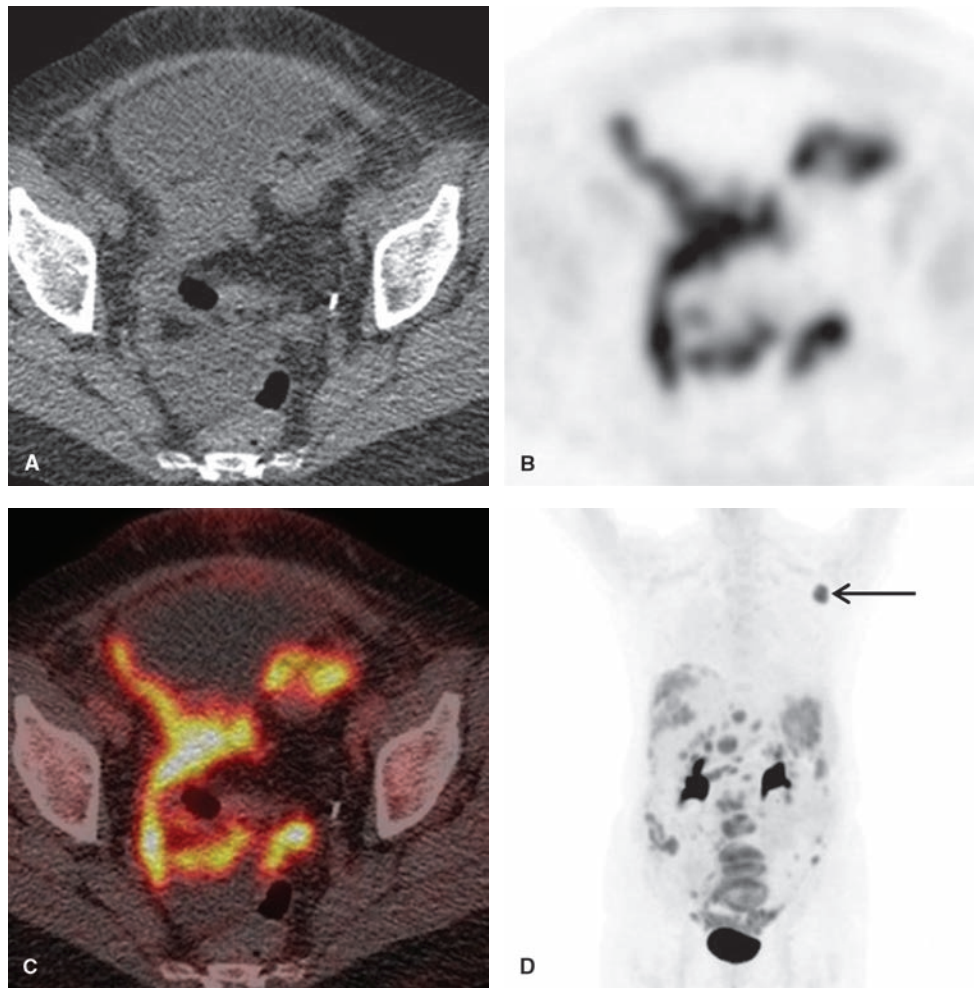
Recurrent ovarian carcinoma. Unenhanced CT image (A), FDG-PET image (B), and fused PET/CT image (C) demonstrate increased tracer uptake along the serosa of the sigmoid colon. Coronal MIP PET image (D) demonstrates widespread increased tracer uptake along the peritoneal and serosal surfaces in the abdomen and pelvis and avid tracer uptake in a left axillary lymph node (arrow in C).
